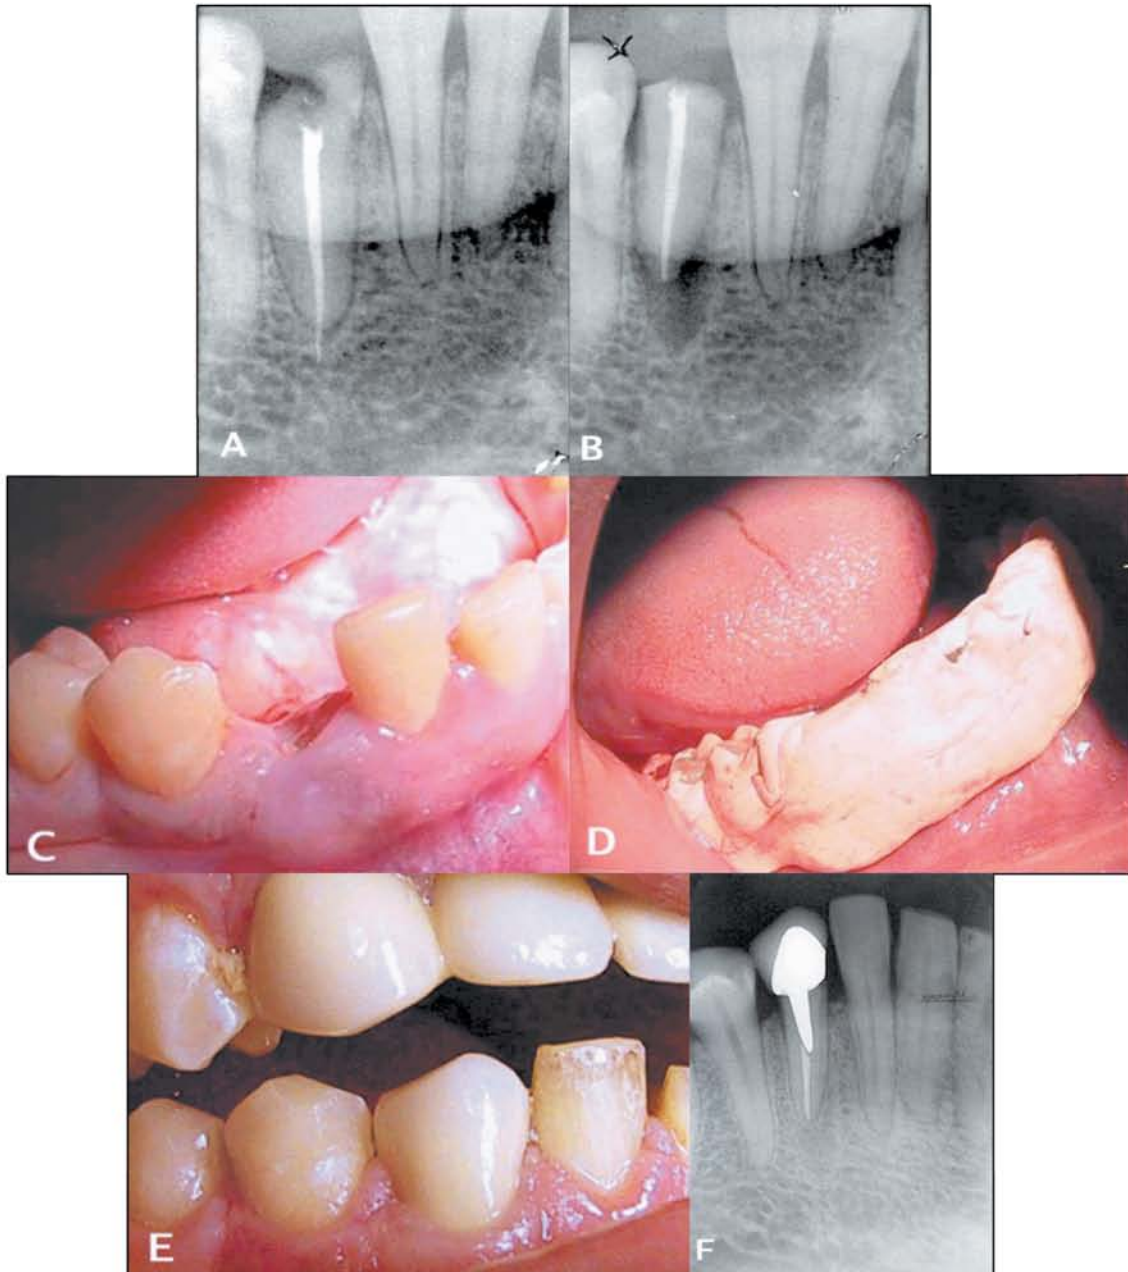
Preoperative radiograph appearance of a crown- root fracture on tooth 27 B. Radiograph appearance following eruption C. Preoperative photograph of crown- root fracture D. Surgical dressing is placed for stabilizing E. After placement of the ceramic core build-up F. No sign of root resorption is seen 12 months after transplantation.
